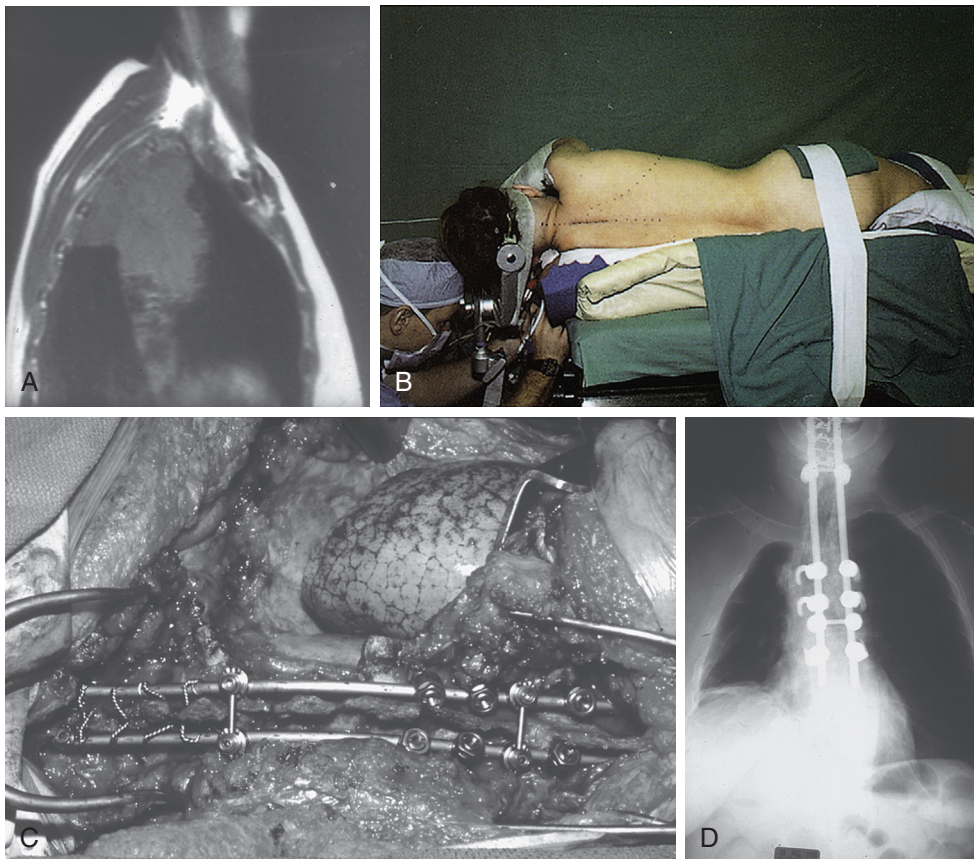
■ A, A lateral chest radiograph demonstrating a large right upper lobe lung cancer with involvement of the chest wall and T1 through T3 vertebral bodies. B, Operative positioning of the patient with the head in cervical tongs to immobilize it and to maintain the alignment of the cervical and thoracic spines. The patient is additionally secured on a beanbag and taped with the appropriate padding of the anterior superior iliac spine. C, Intraoperative photograph showing the resected chest wall, right upper lobe, and multilevel vertebral body resection with reconstruction with posterior rods and anterior stabilization. D, Chest radiograph posteroanterior demonstrating postoperative instrumentation.
